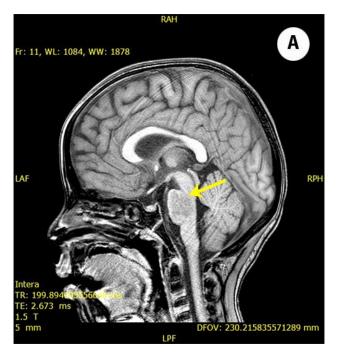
Sagittal T1-weighted brain MRI image shows pontine lesion with low signal intensity.
